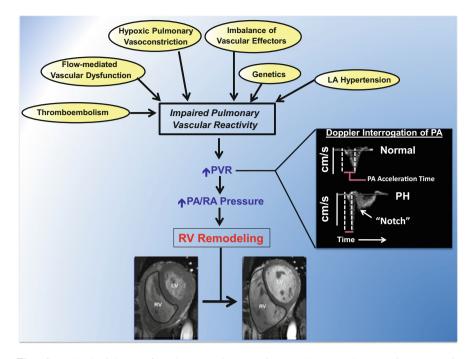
Pathophysiology of pulmonary hypertension. Pulmonary hypertension (PH) is characterized by impaired pulmonary vascular reactivity due to a heterogeneous range of pathological cellular/molecular processes that mediate pulmonary vascular injury. Pulmonary vascular dysfunction in PH is detected clinically by elevations in pulmonary vascular reactivity, which may be assessed invasively by cardiac catheterization or noninvasively by transthoracic echocardiography (inset). Under normal conditions, Doppler interrogation of the pulmonary artery outflow tract results in a broad-based triangular signal envelope. In the presence of decreased vascular compliance, as is the case in moderate to severe forms of PH, the time to peak blood flow acceleration is decreased (PA acceleration time) and a reflected (i.e., retrograde) Doppler signal is detected as a mid- or late-systolic 'notch.' Increased right ventricular (RV) pressure loading results in geometric conformational changes to the RV cavity (outlined in black) as well as RV hypertrophy and systolic dysfunction. LA left atrial, PA pulmonary artery, RA right atrial, cm/ s centimeters/second. Cardiac magnetic resonance images are reproduced with permission from Fernandez-Friera L, Alvarez-Garcia A, Guzman G et al. (2011) Apical right ventricular dysfunction in patients with pulmonary hypertension demonstrated with magnetic resonance. Heart 97:1250-1256
